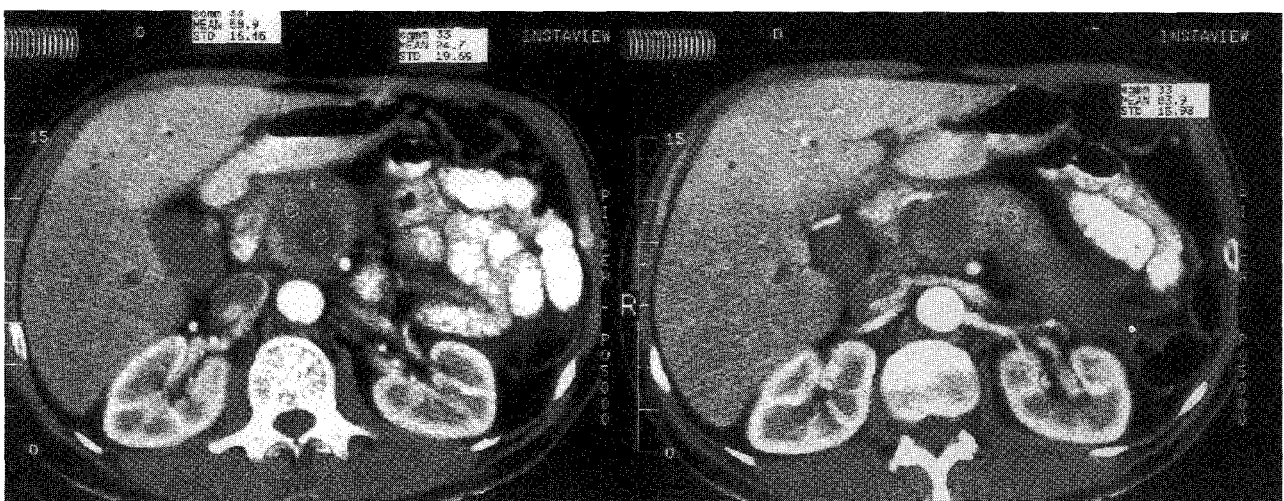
Abdominal CT scan of patient 2, showing a heterogeneous mass in the head of the pancreas (left side) and an enlargement of the pancreatic body and tail (right side).
